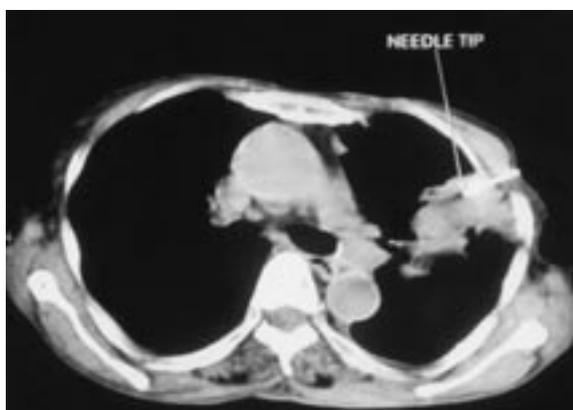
Axial CT image of the thorax shows a soft tissue density lesion in the upper lobe of the left lung with a solitary lymph node in aorto-pulmonary window.
